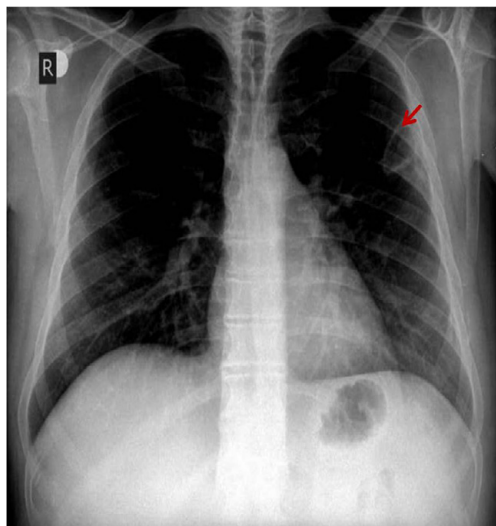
Posterior-anterior chest radiograph showed a subpleural cavitating lesion on the left upper zone.
